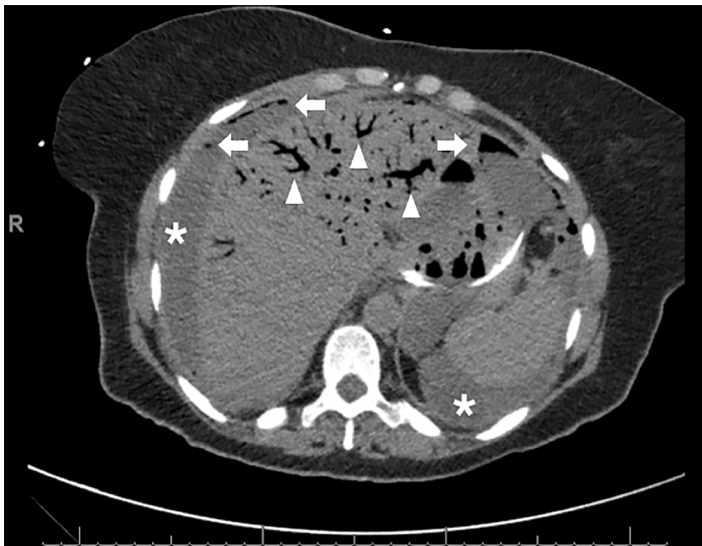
Computed tomography scan of the abdomen revealing extensive ascites (*), intraperitoneal free air (arrows), and extensive branching portal venous gas (triangles), indicative of bowel ischemia, necrosis, and perforation.
